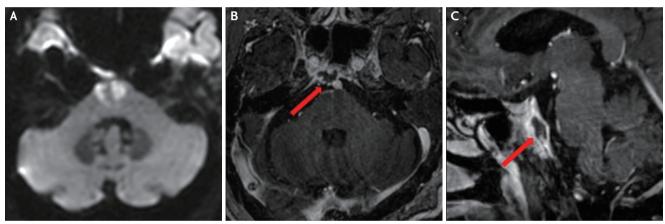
(A) Diffusion-weighted MRI on the initial day showing bilateral pontine infarction. (B, C) T1-weighted contrast-enhanced MRI taken on the 3rd day, demonstrating clival osteomyelitis with contrast enhancement and a rim-enhanced abscess in close proximity to the basilar artery (red arrow). MRI, magnetic resonance imaging.
